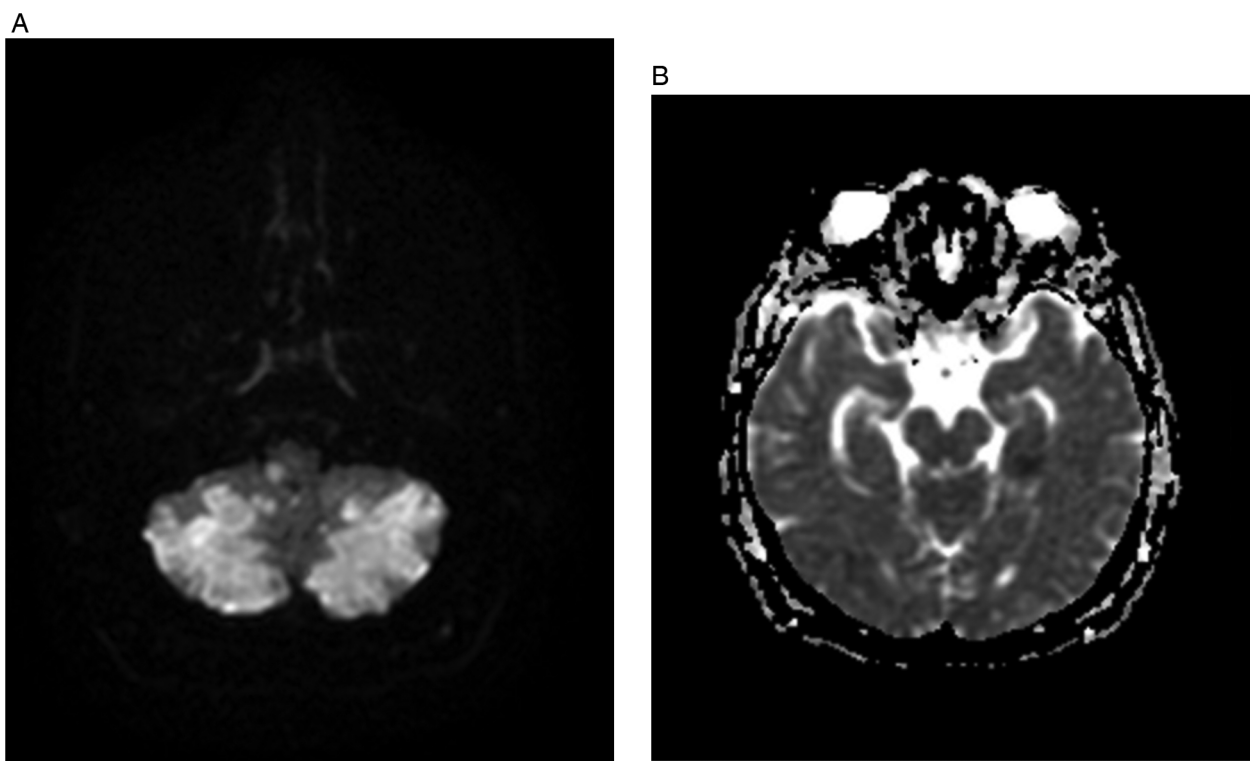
(A and B) Diffusion MRI findings concordant with acute phase infarct in B1000 (A), and apparent diffusion coefficient map.
